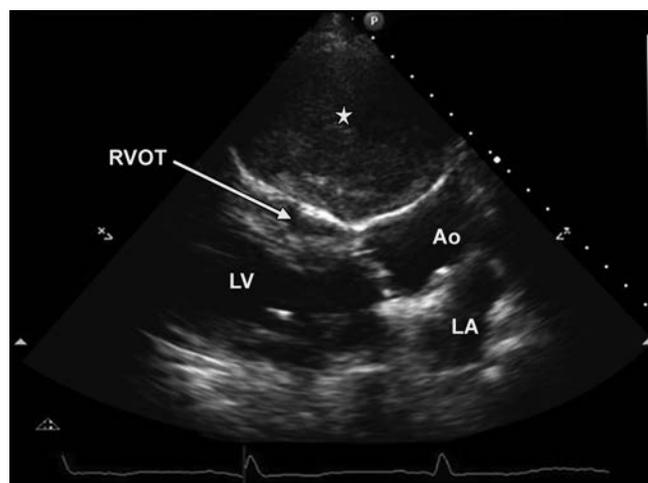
2D TTE. Parasternal long-axis view showing a large pseudoaneurysm (star) compressing the right ventricular outflow tract (RVOT). (LV: Left ventricle; LA: Left atrium; Ao: Aorta).
